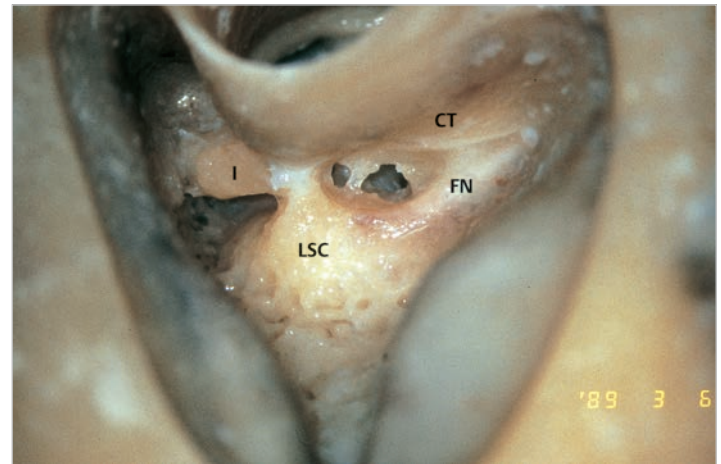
The facial nerve and the chorda tympani are skeletonized. Posterior tympanotomy is partially carried out by removing bone between two nerves. CT, chorda tympani; FN, facial nerve; I, incus; LSC, lateral semicircular canal.
